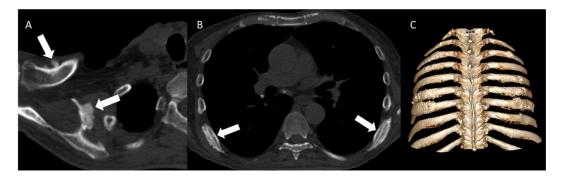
Unenhanced chest CT 4 months after initiation of voriconazole. Axial images (A, B) and 3D reconstruction (C) demonstrate symmetric periosteal reaction along the clavicle, scapula and bilateral mid posterior ribs (arrows).
